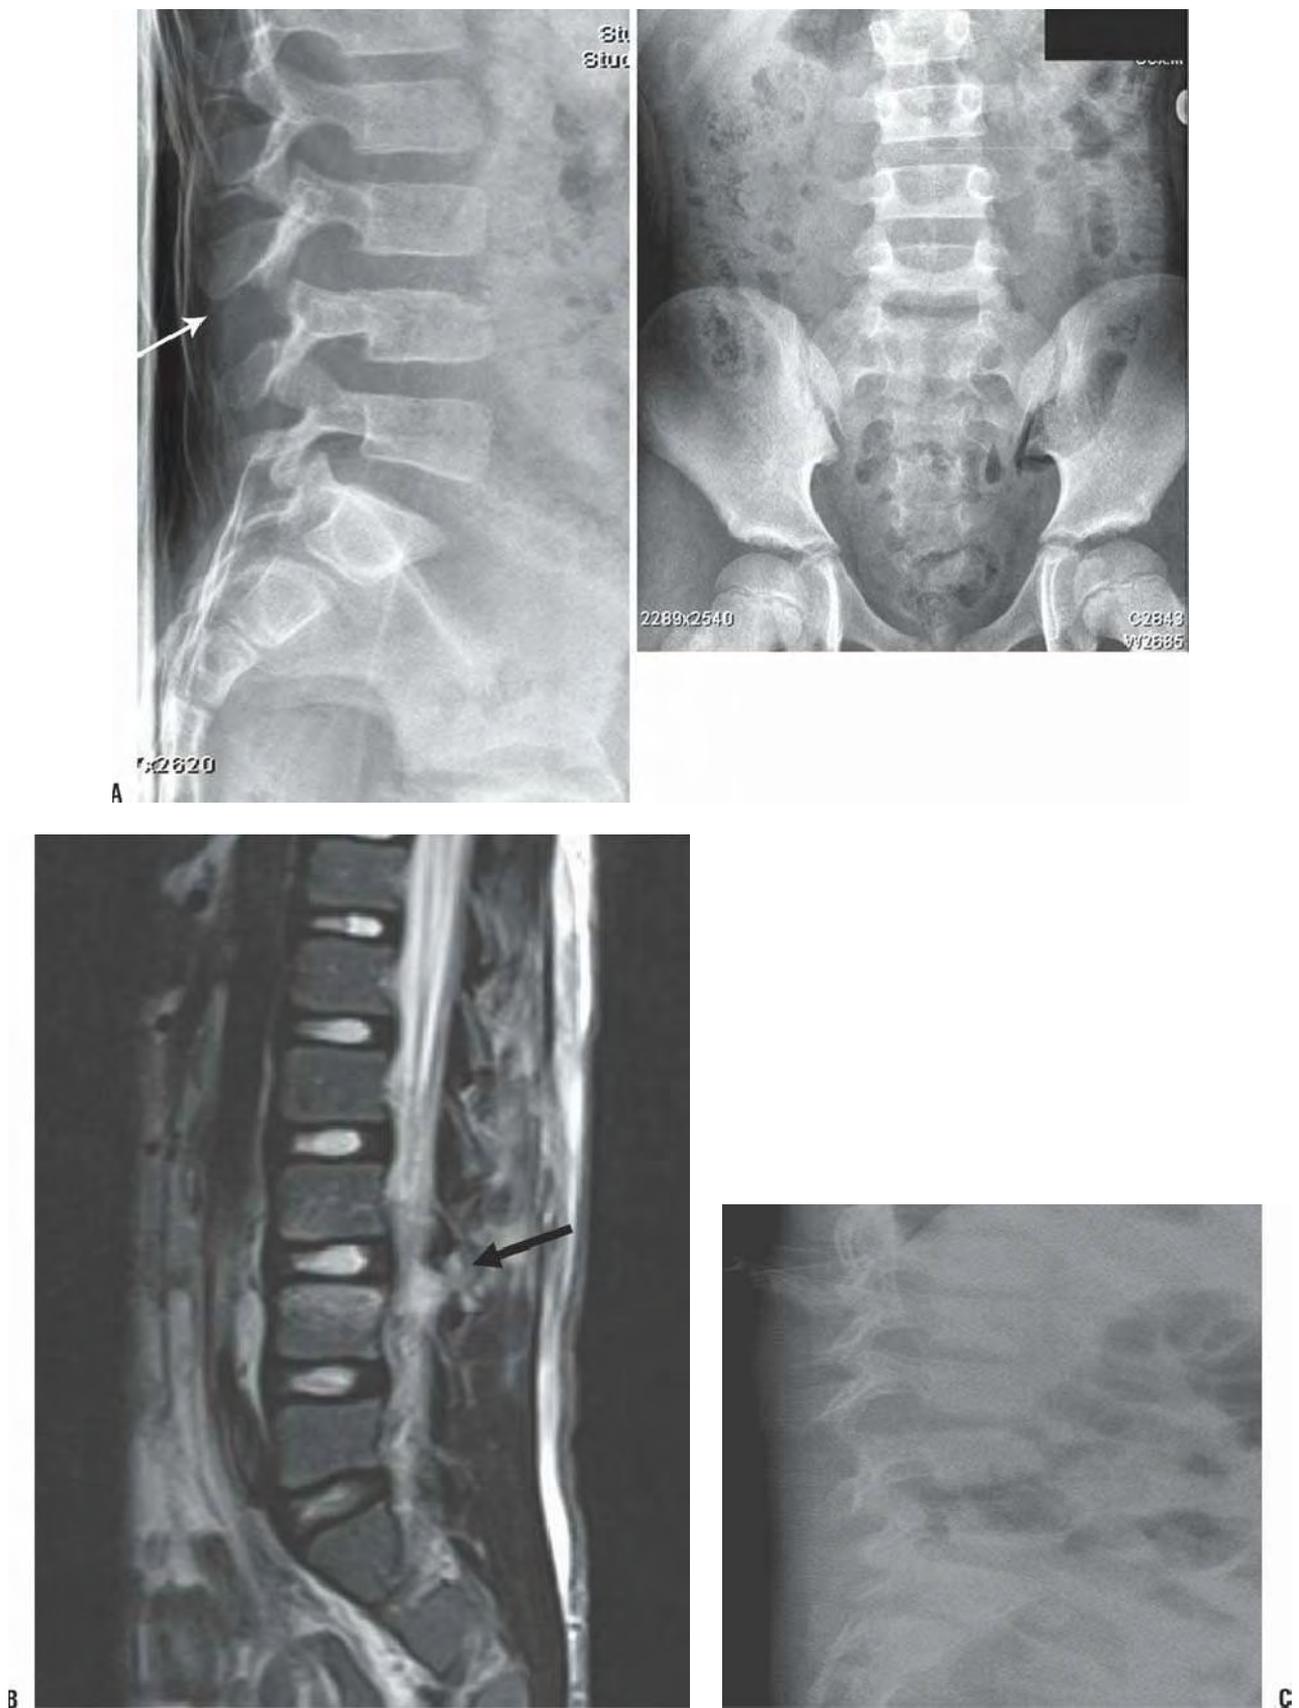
A: Anteroposterior and lateral lumbar spine radiographs of an 8-year-old with a lap-belt injury. There is slight distraction of the spinous processes and posterior swelling. There was also an abdominal injury B: MRI with posterior ligamentous increased signal. C: Close observation with extension cast immobilization as the original treatment revealed the unstable ligamentous characteristics of the Chance injury. A two-level posterior fusion was thus performed.
